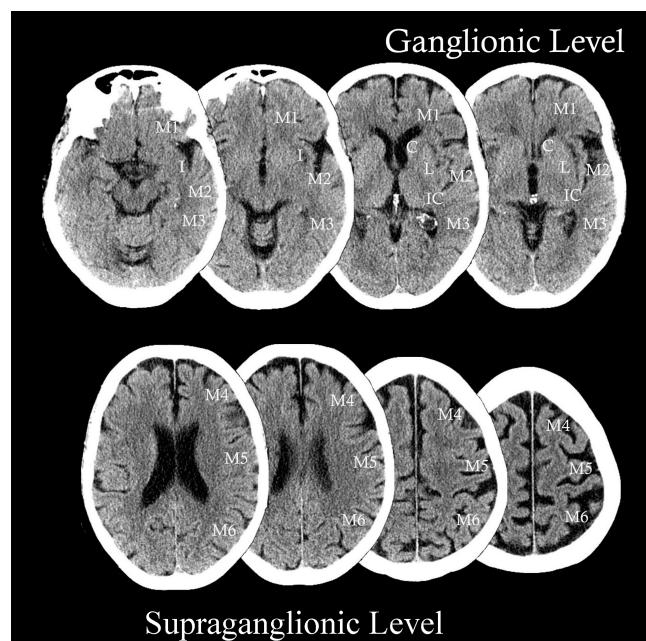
The ASPECTS demarcations
